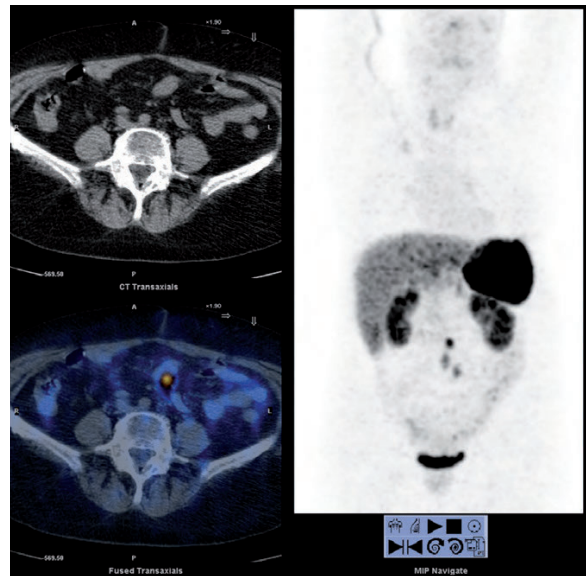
$^{68}\text{Ga}$ -DOTANOC PET/CT images of a patient with biopsy-proven NET metastatic lesions and unknown primary tumour. PET/CT allowed the detection of a focal area of tracer uptake in the ileum wall suspicious for tumour primary site, one abdominal node, one mesenteric nodule and a focal area at the liver level (first segment).  $^{68}\text{Ga}$ -DOTANOC PET/CT showed that all the detected lesions presented an increased expression of SST
